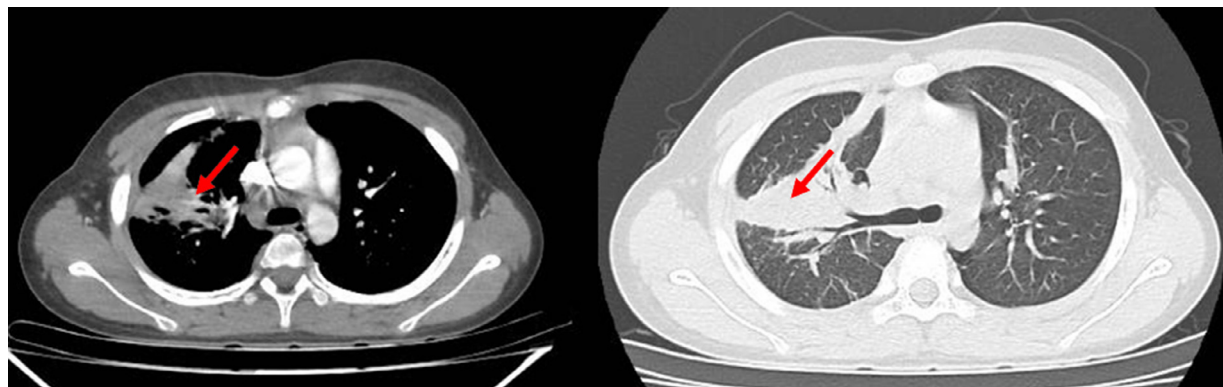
Following up with a chest CT scan, the right consolidation has shrunk significantly (arrow), and the right pleural effusion has almost totally disappeared.
